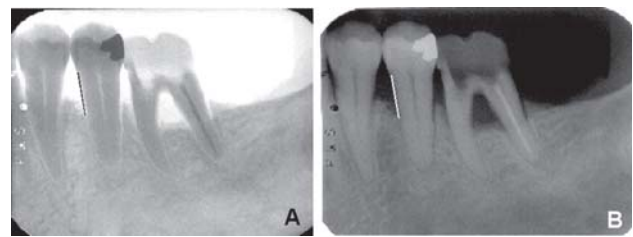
Digitized radiographic images: inverted (A) and unprocessed (B) showing the bone loss measurements (black and white lines), from the cement enamel junction to the most apical extension of the bone loss
